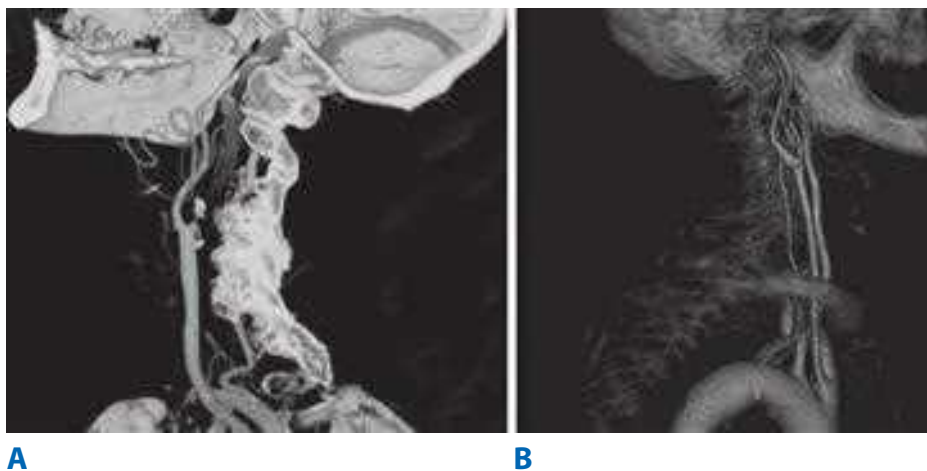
A. Carotid computed tomography angiography is a valuable imaging modality that can provide a three-dimensional image reconstruction with high image resolution. A carotid artery occlusion is noted in the internal carotid artery B. The entire segment of extracranial carotid artery is visualized from the thoracic compartment to the base of skull.
